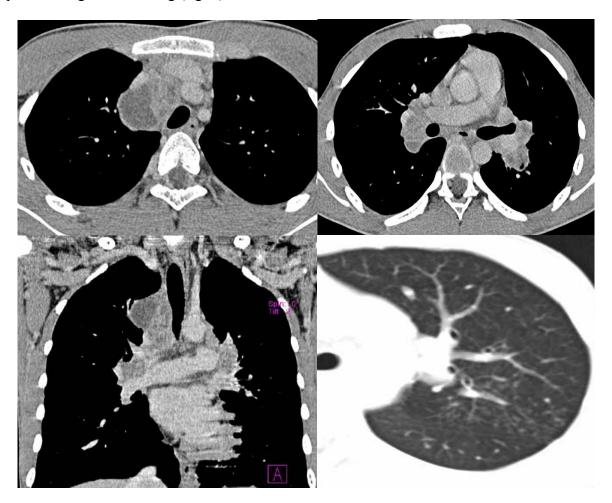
Computed tomography of the lungs and mediastinum. Tumor-like form of tuberculosis of the intrathoracic lymph nodes, complicated with lymphohematogenous seeding.
